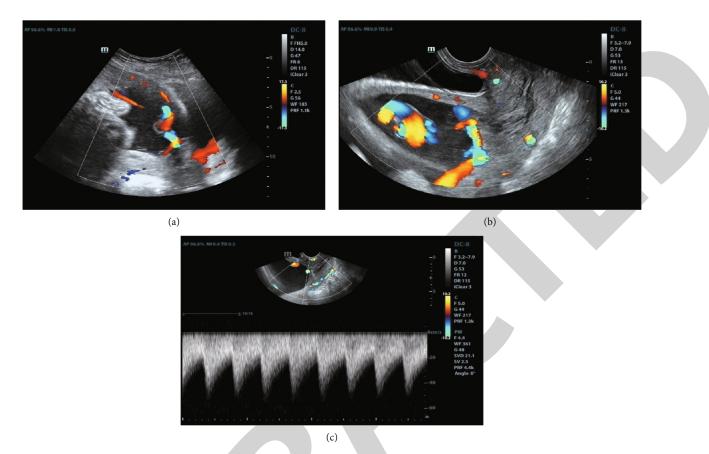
Color Doppler ultrasonography indicated the patients with VP + VCI (gestational week: 34+ 4 weeks; age: 31 years). Note: (a) TA-CDUS: the placenta was located on the posterior wall of the uterus near the internal os. (b) TV-CDUS: The umbilical vessel was fixed at the internal os with the adherence of the placenta to the posterior region, (c) The Doppler spectrum of the blood vessels above the internal os was consistent with the umbilical artery spectrum.
